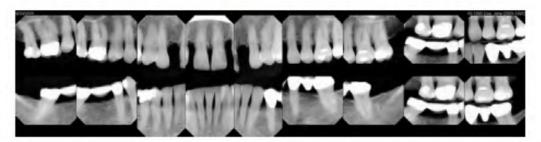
A typical postmortem full-mouth (digital) x-ray series.
